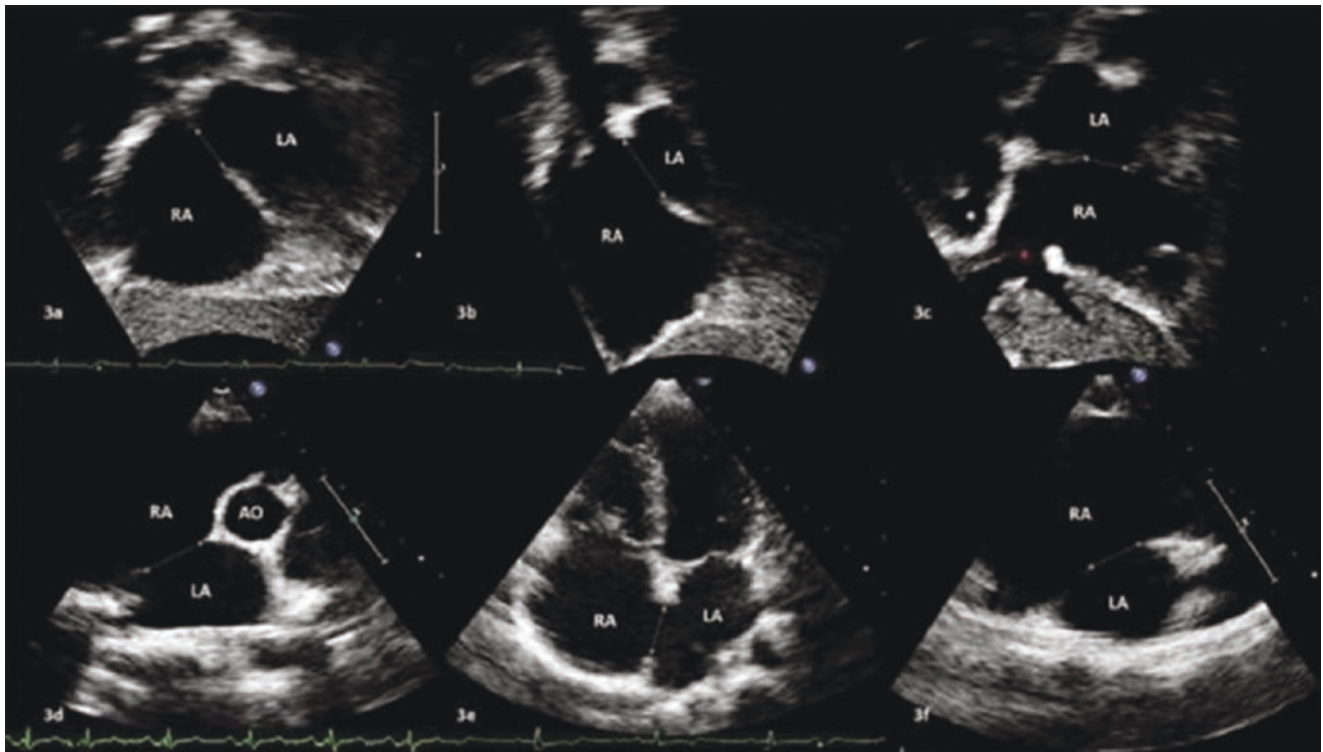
Transthoracic echocardiographic images of ASD. Panels 3a–3c are 2D transthoracic echocardiographic images from the subxiphoid window. Panel 3d is the parasternal short-axis projection showing the aortic rim of the ASD. The mitral rim of the ASD is notable in the apical
